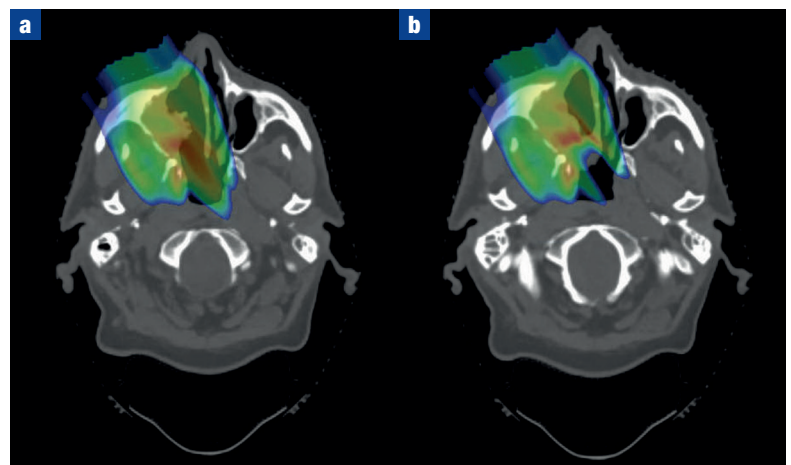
a. Planning computed tomography scan and (b) repeat computed tomography scan. The effect of anatomical changes on the planned dose distribution for a single beam in the nasal cavity. Where the beam passes through a higher density region than was present on the computed tomography scan the result is a distortion of the planned dose distribution which may necessitate plan adaptation.
